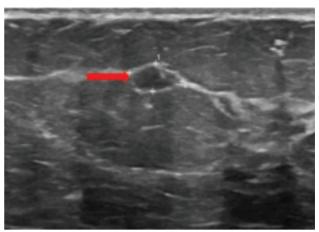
Magnetic resonance imaging-directed ultrasound scan of the left breast reveals a small irregular mass at the 1 o'clock position, 10-11 cm from the nipple (red arrow)
